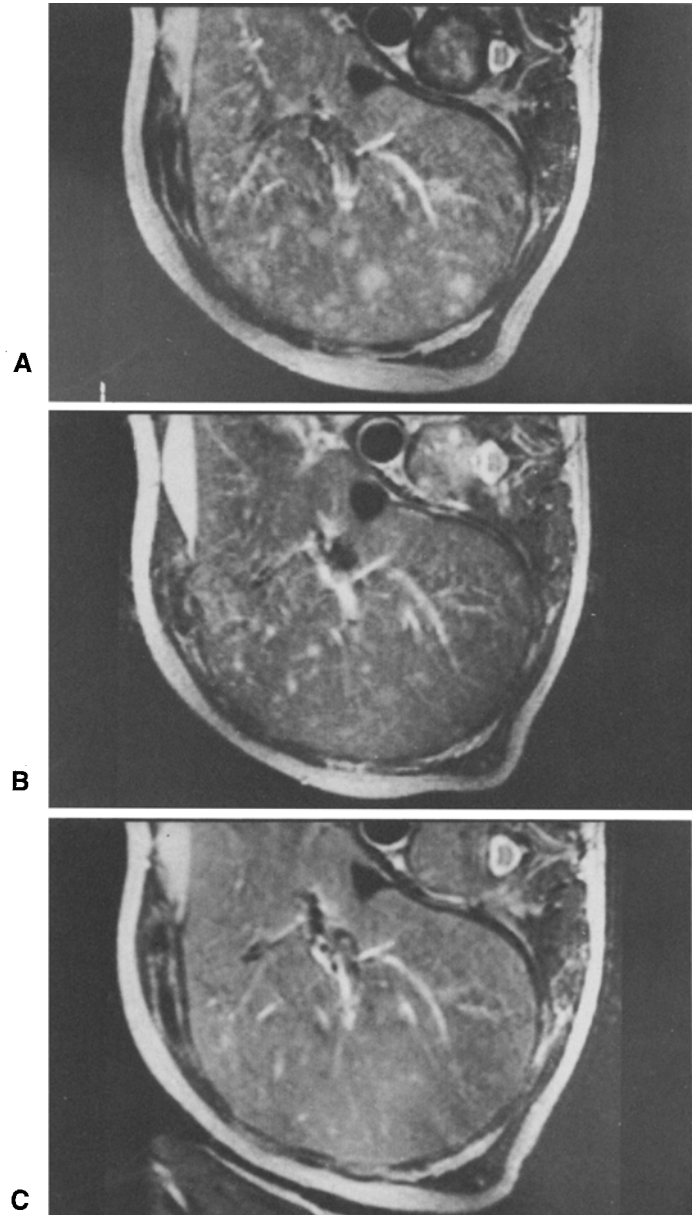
MRI scans of the upper abdomen in a patient (patient 11 in Table 1) treated with histamine in addition to immunotherapy with interleukin-2 and interferon α : before treatment (A), after four cycles (B), and after seven cycles of treatment (C)
